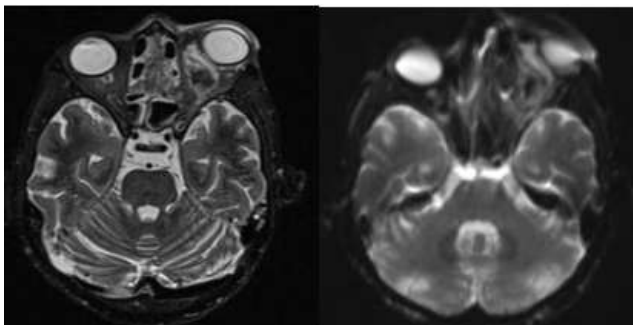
MRI orbit shows left orbital intraconal lesion in superomedial aspect showing diffusion restriction on DWI consistent with intraconal abscess
